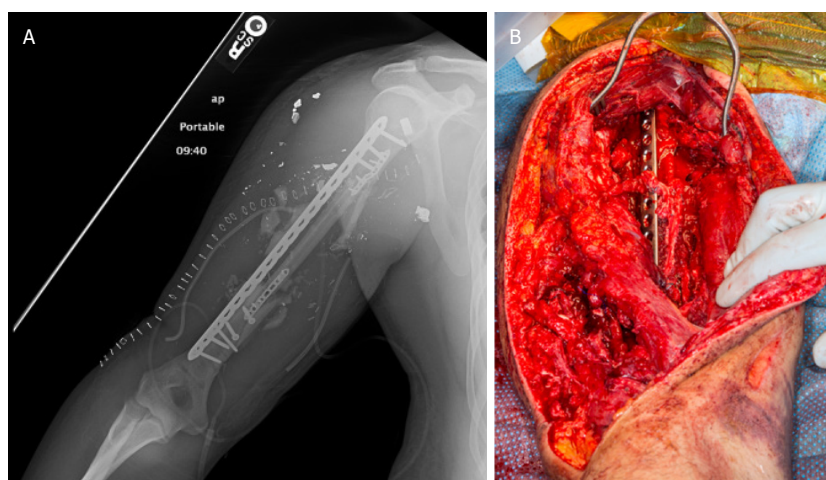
A: radiograph showing fixation of free fibula graft; B: Intraoperative photograph after fixation of free fibula graft
